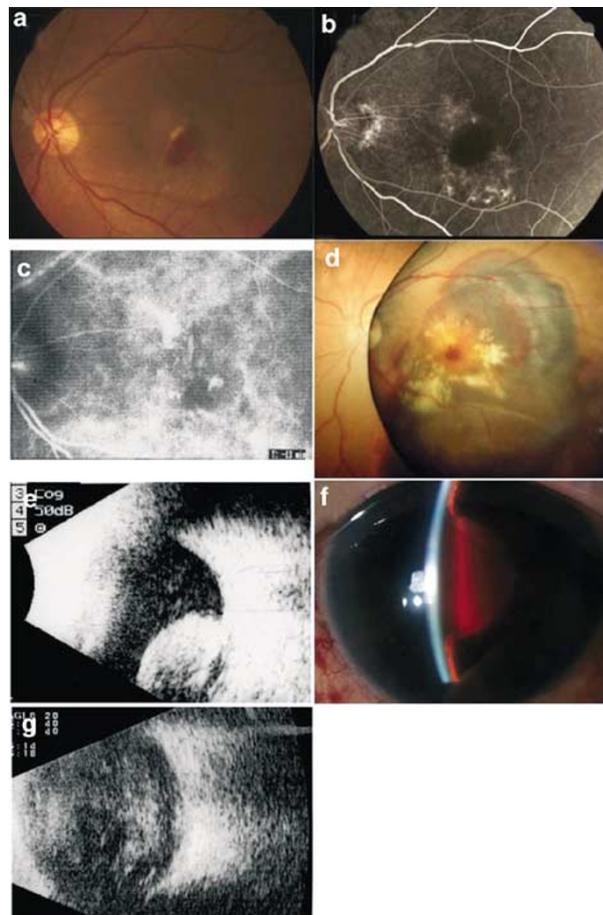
Dilated fundus examination (a) revealed subretinal haemorrhage in the macular area at our recent observation. Fluorescein angiography (b) and indocyanine green angiography (c) disclosed a persistent occult choroidal membrane not suitable for treatment. At initial presentation to our clinic, the dilated fundus examination disclosed a massive subretinal haemorrhage (d). After 1 month, massive subretinal haemorrhage was seen as high reflex on B-mode ultrasonography (e) and slit-lamp examination showed massive subretinal haemorrhage reaching the posterior capsule of the lens (f). At 1 week thereafter, the subretinal haemorrhage reached the posterior capsule of the lens as shown by B-mode ultrasonography (g).
